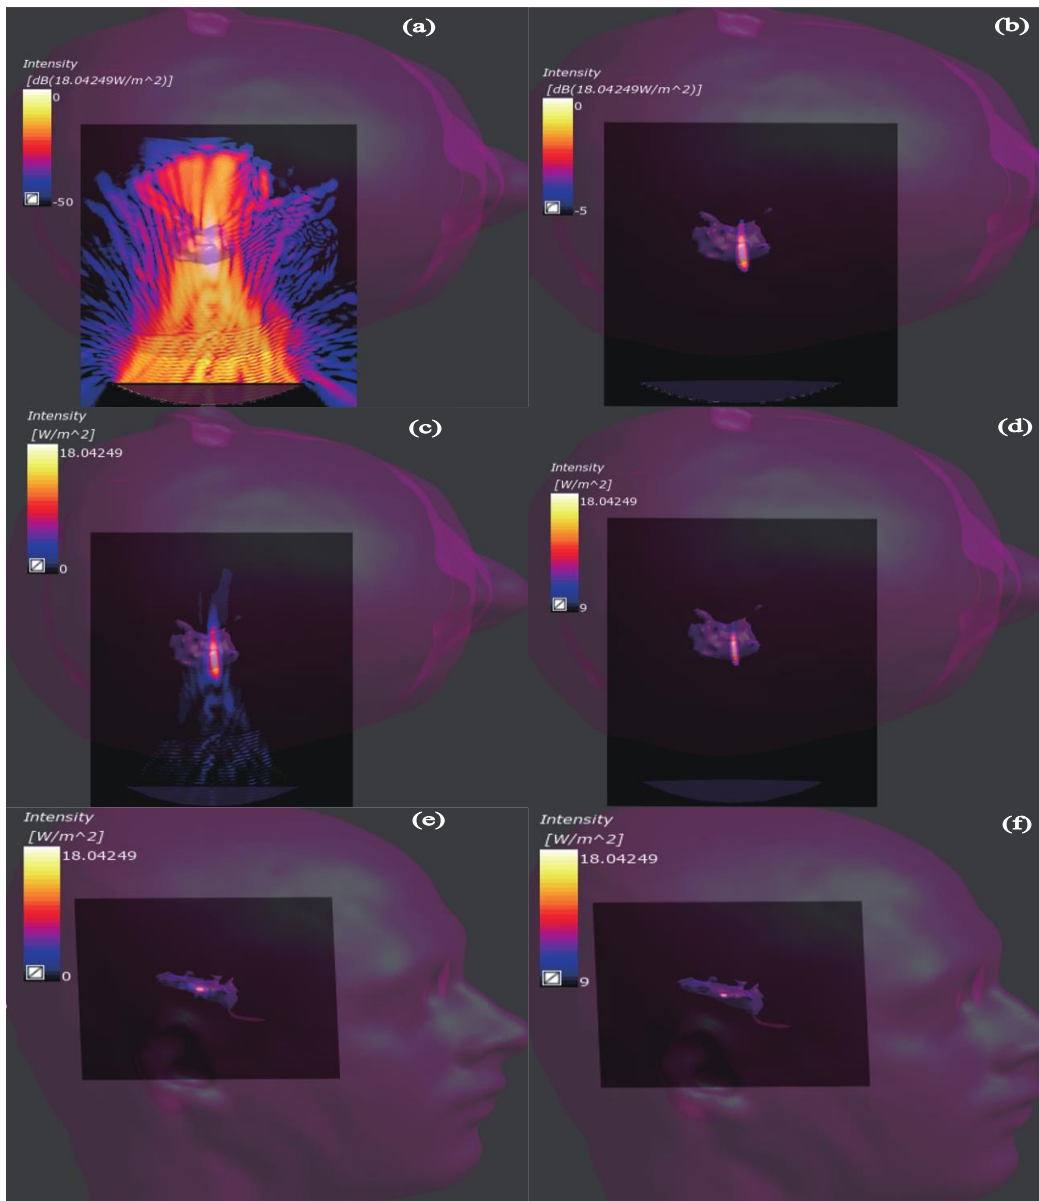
Results of ultrasound propagation with intensity distribution and corresponding FWHM region. Intensity distribution in the XY plane in dB reference (18 W/m^2) from 0 to -50 dB (a), from 0 to -5 dB (b). Intensity distribution in the XY plane, from 18 to 0 W/m^2 (c) and from 18 to 9 W/m^2 (d). Intensity distribution in the YZ plane, from 18 to 0 W/m^2 (e) and from 18 to 9 W/m^2 (f).
